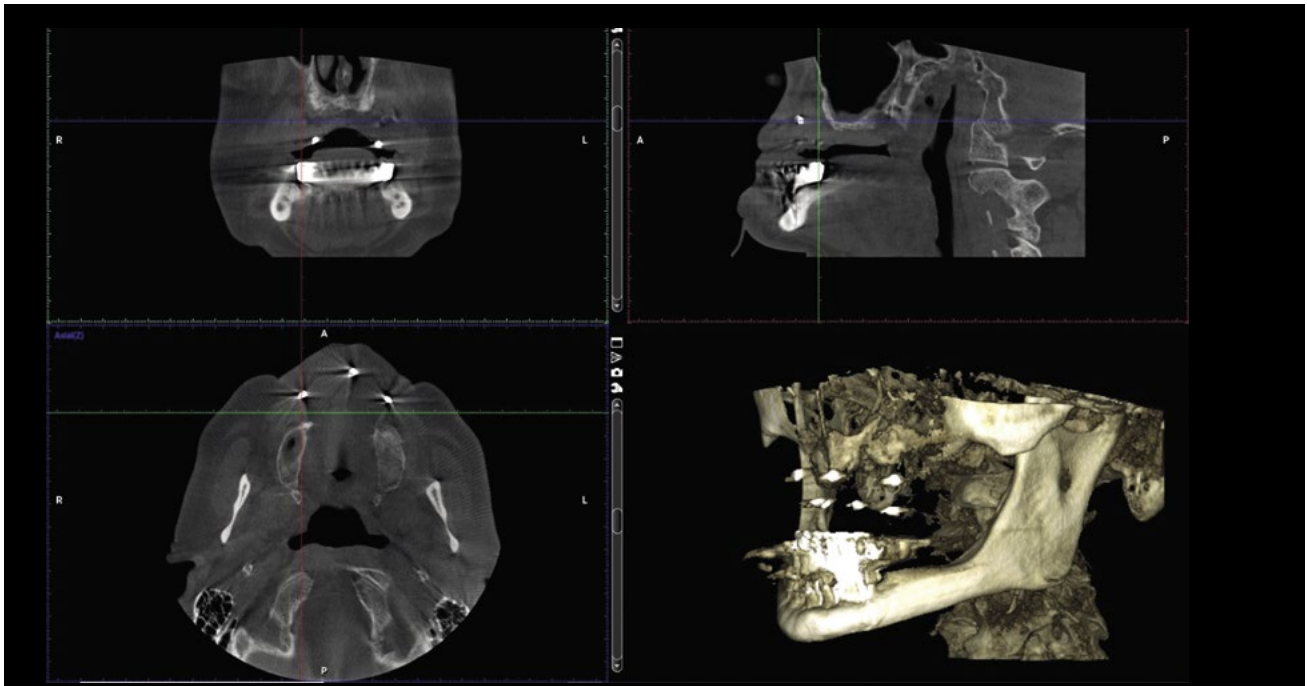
The patient CBCT with complete prosthesis and gutta-percha markers.
